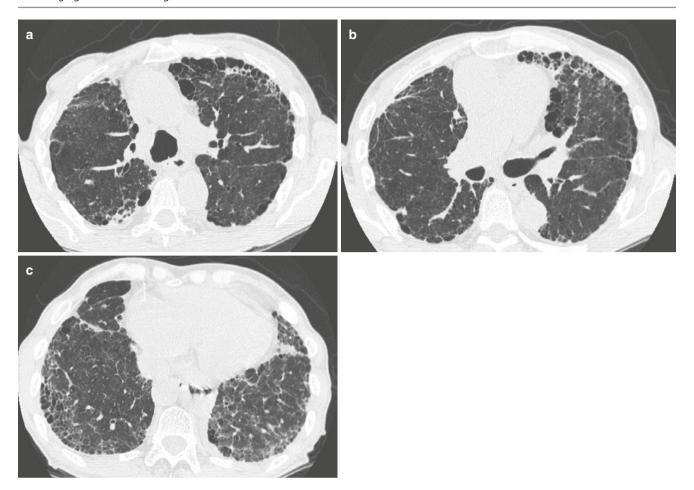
HP mimicking UIP in a nonsmoker with exposure to pigeon's droppings. (a–c) Axial CT images show honeycombing with mild centrilobular nodularity. The honeycombing is more severe in the upper and mid-lung
